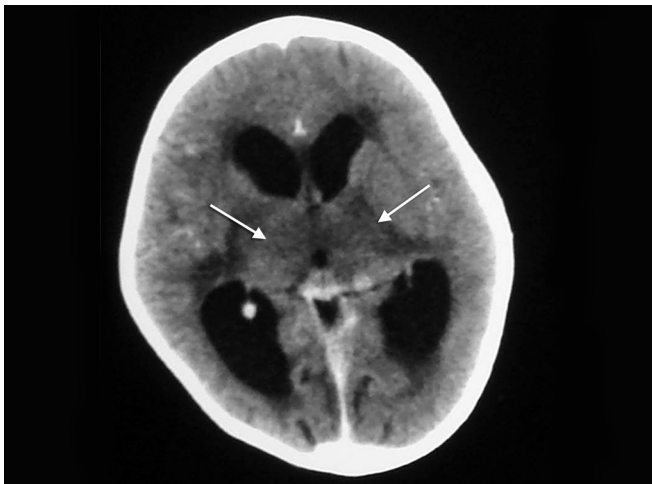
Axial contrast enhanced CT image of the brain at the level of basal ganglia shows hypodensities in bilateral thalami (arrows) consistent with infarcts. Note: The dilated lateral ventricles with periventricular hypodensities (ooze)
